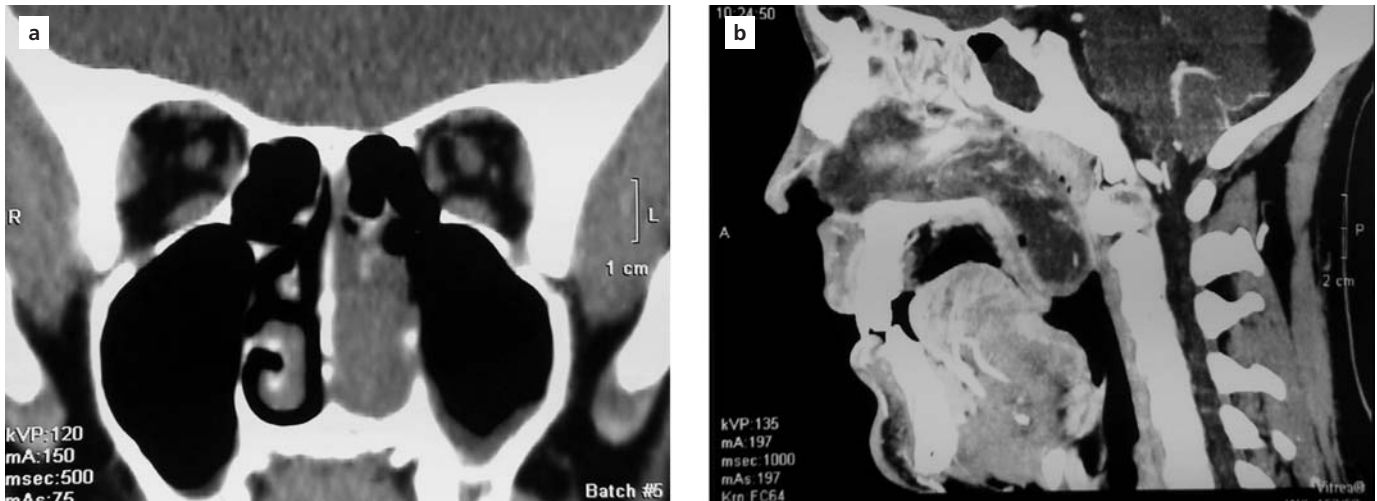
(a) Coronal CT scan shows soft tissue lesion arising from the inferior part of the left middle turbinate extending to the choana. Note that the left maxillary and ethmoid sinus is clear. (b) Sagittal contrast-enhanced CT scan shows a giant soft tissue mass involving nasal cavity and extending to the nasopharynx which is completely filled by lesion. Note the presence of small feeding vessels and the absence of rich, irregular vascular supply characterized for angiofibroma.
